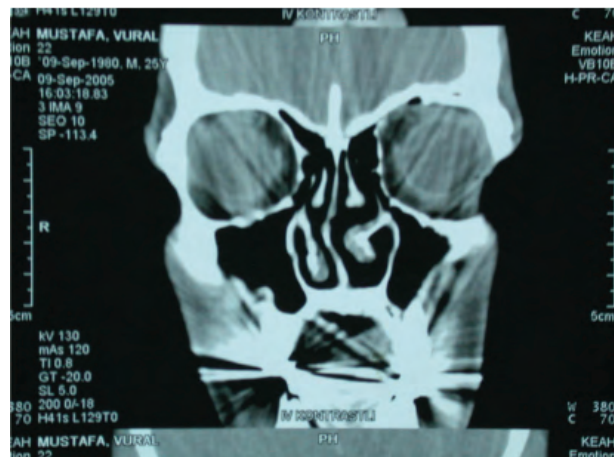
Coronal CT scan 4 months postsurgery.
